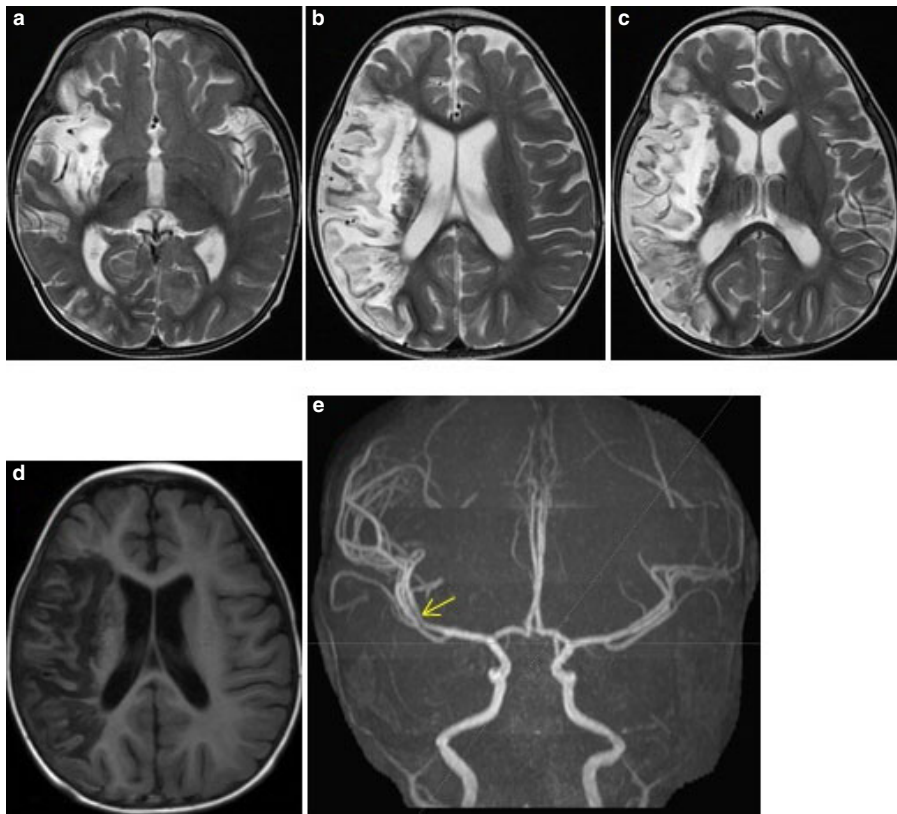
Brain magnetic resonance angiography showing (a–c) large hyperintense T2-weighted lesion and (d) hypointense T1 imaging with gyral enhancement involving the right fronto-parieto-temporal lobe, right caudate nucleus, right lentiform nucleus, right internal and external capsule, and right insular lobe; (e) short segmental mild stenosis at the proximal M2 segment of the superior and inferior branches of the right middle cerebral artery. The rest of the intracranial and cervical vessels appeared normal.
